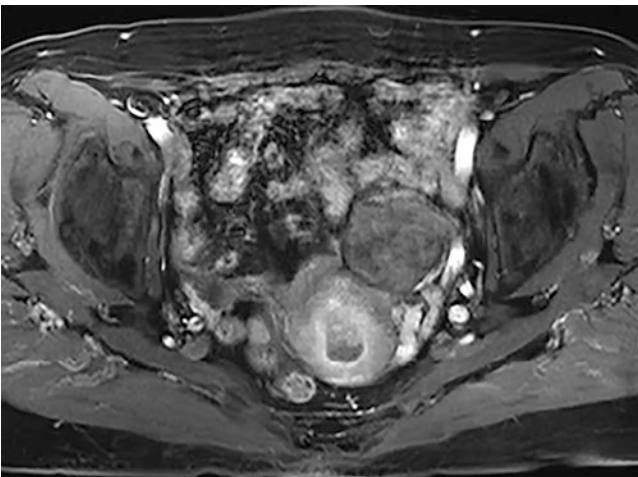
T1-weighted contrast-enhanced image showed the mass enhanced less than myometrium
